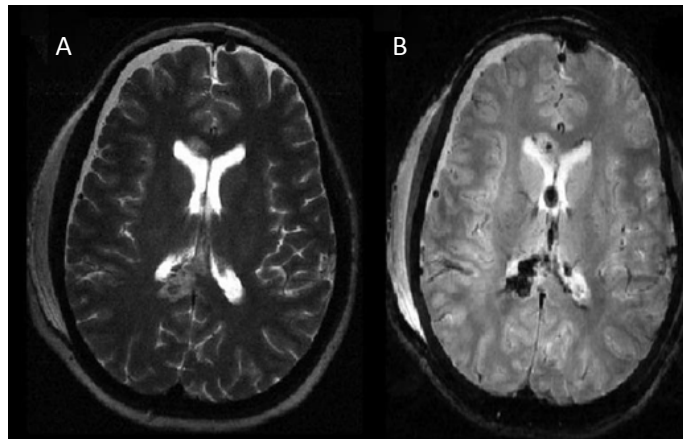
T2 (A) and FLAIR (B) axial images showing a right subacute subdural haematoma, right sided superficial scalp swelling and periventricular lesions in the corpus callosum consistent with DAI. The periventricular lesions are more easily identified on the FLAIR image, than the T2 image (Coles, 2007).
